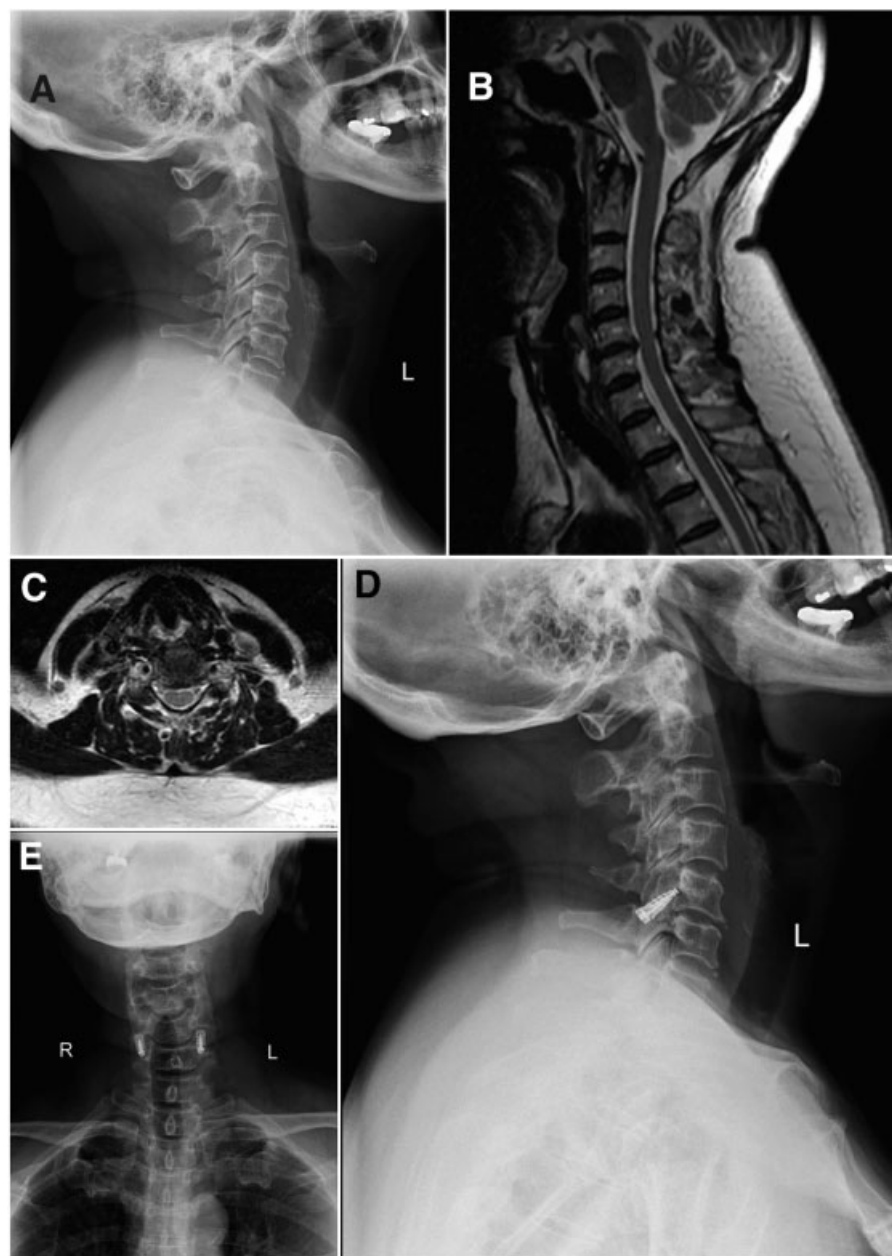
(A) Lateral preoperative radiograph of a 56-year-old woman with upper extremity radiculopathy demonstrating C5–C6 intervertebral disk space degeneration. Cervical alignment is lordotic. (B) Sagittal preoperative magnetic resonance imaging (MRI) demonstrating C5–C6 intervertebral disk herniation without spinal cord compression. (C) Axial preoperative MRI demonstrating C5–C6 disk herniation with no spinal cord compression. (D) Two-year postoperative lateral radiograph demonstrating C5–C6 DTRAX Expandable Cage. No evidence of new adjacent segment degeneration. (E) Two-year postoperative anteroposterior radiograph demonstrating C5–C6 DTRAX Expandable Cage.
